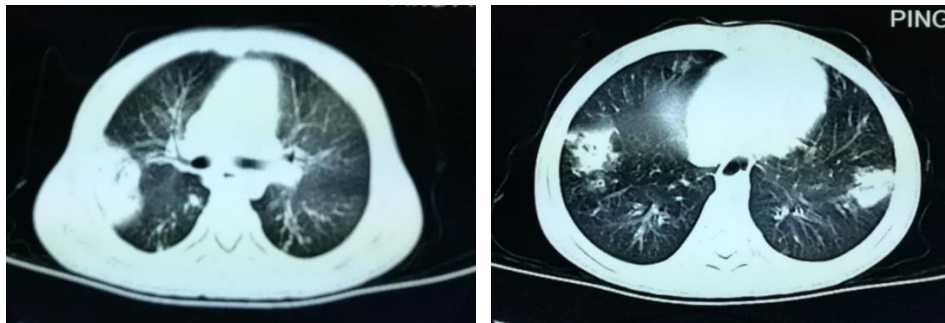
Chest CT scan of the CF patient. Chest CT scans showed obvious exudative lesions and bilateral bronchiectasis in lung of the CF patient.
